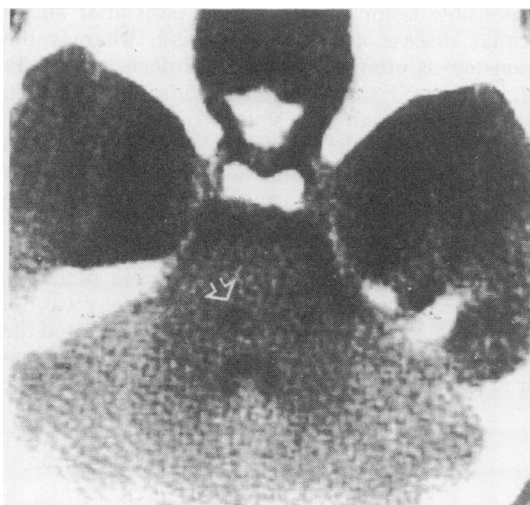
Figure CT scan showing left paramedian infarct in the basis pontis (arrow).
